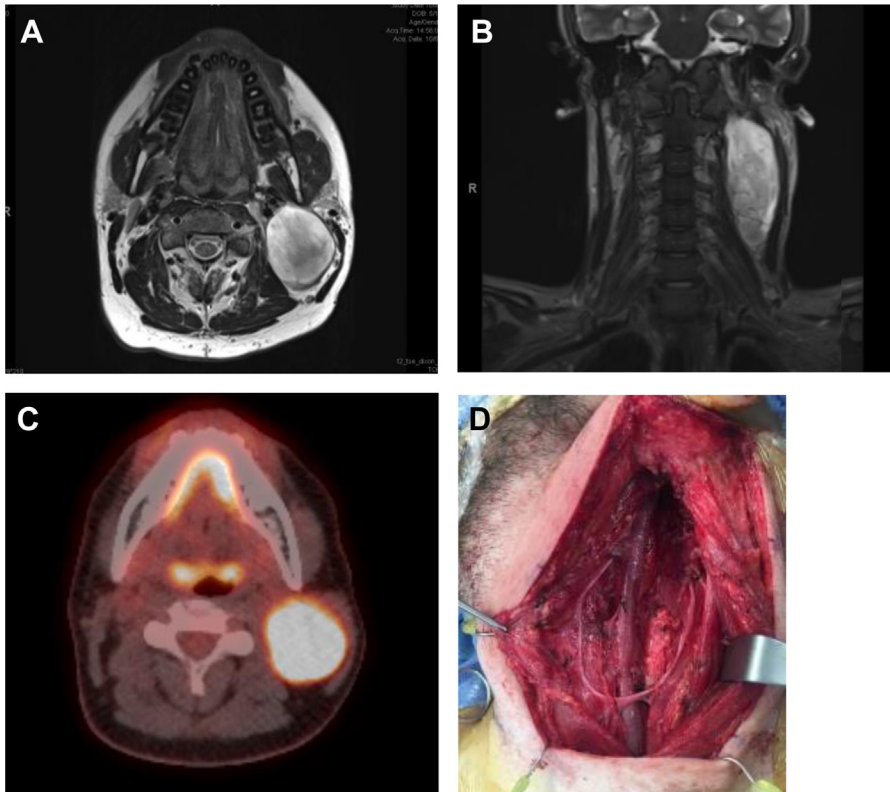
Neck/skull base, lower cranial nerves. (A) Axial T2 weighted MRI with large left neck mass. (B) Coronal T2 weighted MRI demonstrating left neck mass extending along carotid space to skull base. (C) FDG PET with PET-avid lesion in left neck. (D) Intraoperative photo of left ansa-cervicalis post-tumor resection before RLN-ansa anastomoses.
